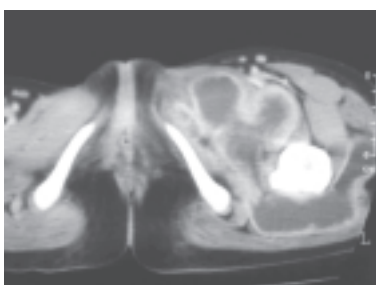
Enhanced axial CT scan taken at the level of the femoral lesser trochanters.
